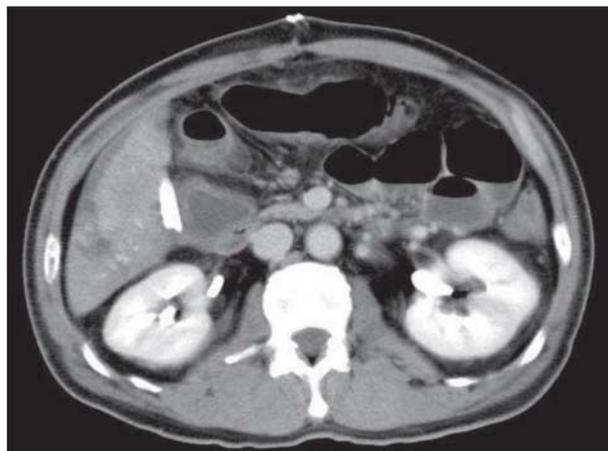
A computed tomographic scan shows sporadic hepatic infarction.
